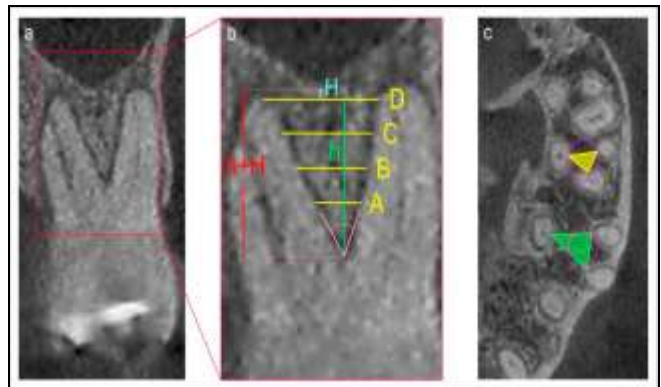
CBCT Scans of the Maxillary Molar Region in the Coronal View. a) CBCT Image b) Landmarks of CBCT Image c) Axial View
